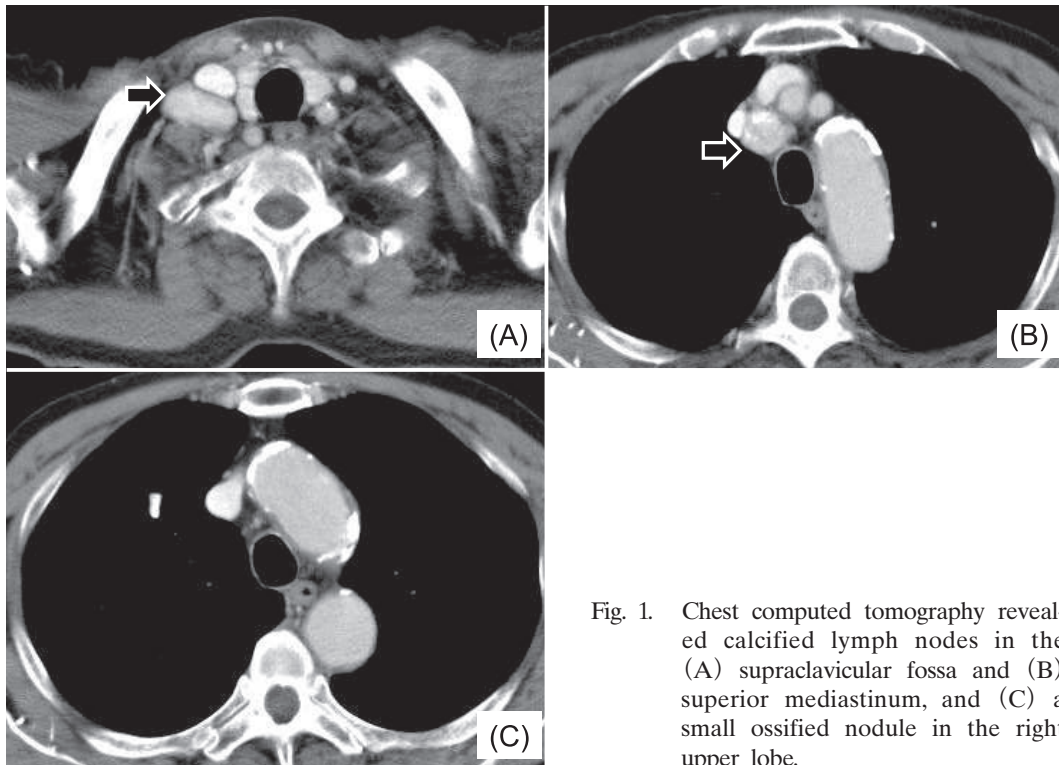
Chest computed tomography revealed calcified lymph nodes in the (A) supraclavicular fossa and (B) superior mediastinum, and (C) a small ossified nodule in the right upper lobe.
